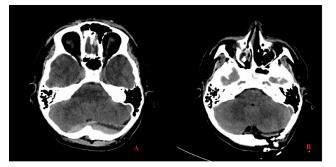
A) Preoperative CT scans revealing a large bilateral PFEDH in a 16-year old boy, displacing the fourth ventricle B)Postoperative CT scans obtained in the same patient
